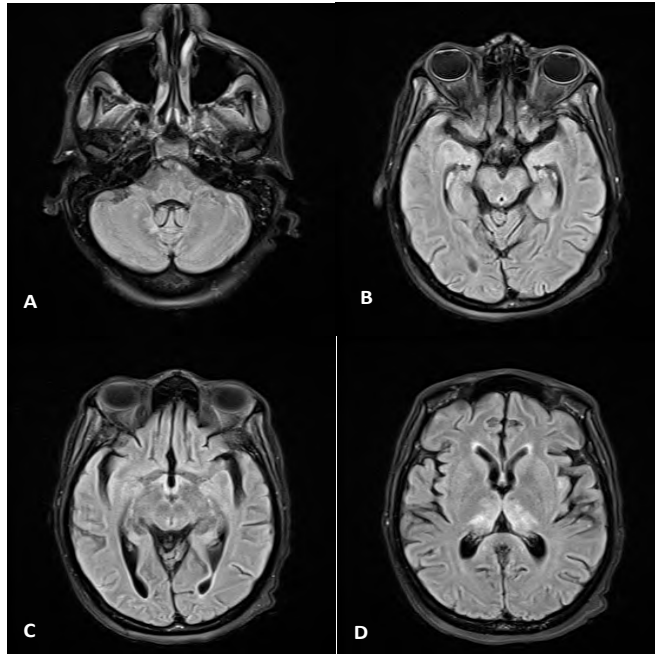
T2 FLAIR findings on MRI showing high signal intensity at the cerebellum (A), mammillary bodies (B), periaqueductal gray matter (C) and medial thalami and periventricular region of the third ventricle (D)
